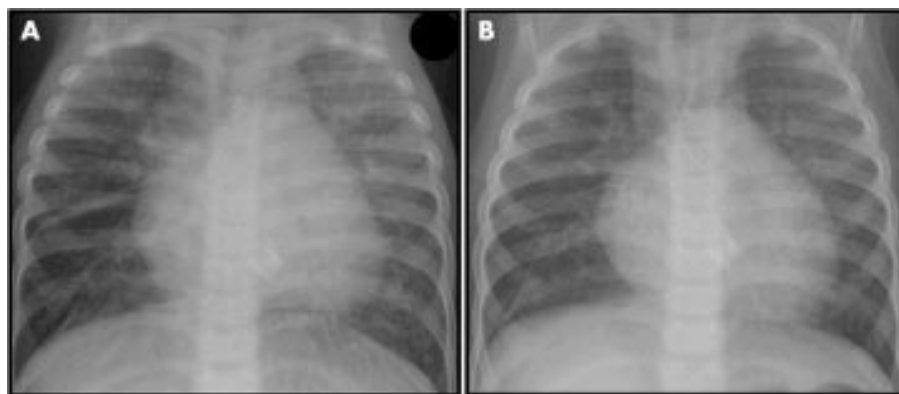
Chest radiograph (A) before and (B) two months after repeat balloon dilatation and intrastent sonotherapy.
